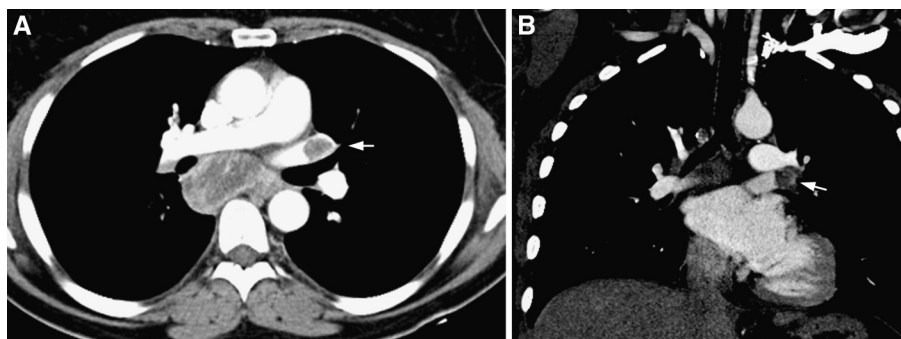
Intracardiac tumour thrombus. Axial (A) and coronal (B) computed tomography reconstructions in a 65-year-old woman with metastatic ovarian cancer, showing subcarinal lymphadenopathy and tumour thrombus in the left superior pulmonary vein (arrows).
